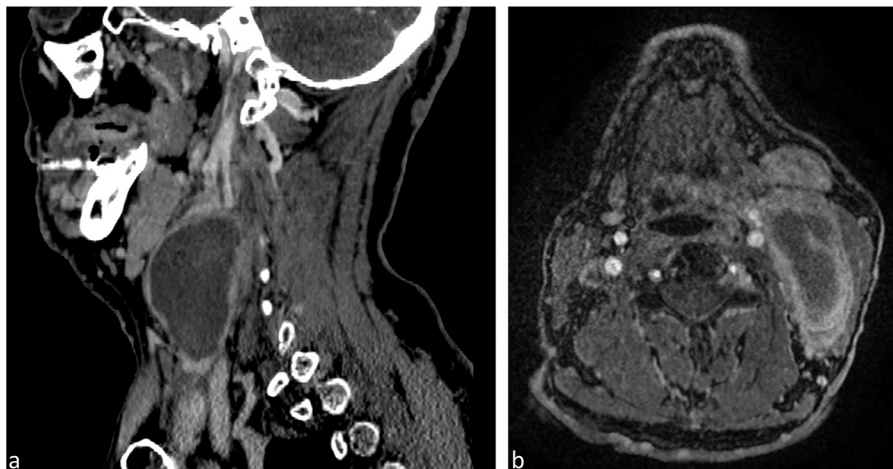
(a) CT neck scan sagittal plane showing a mass exerting pressure to left internal jugular vein (b) MRI neck scan axial cut. Hematoma with possible leakage from the left internal jugular vein.
